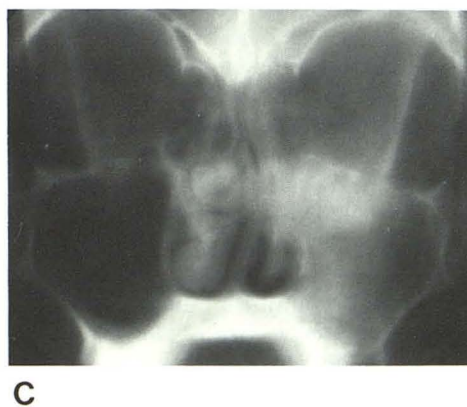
Sinus infection and osteomyelitis after tooth extraction. A, Sequential axial CT sections. Multifocal bone resorption of maxillary antrum floor and walls. B, Coronal reformation. Destruction of orbital floor and extension of inflammation into retroorbital fat (arrows). C, Conventional tomographic study 1 day before CT. Maxillary sinus and ethmoid opacification seen; bony involvement suggested. Orbital findings on CT actually preceded clinical development of ophthalmoplegia by 8 hr and altered surgical treatment (see text).
